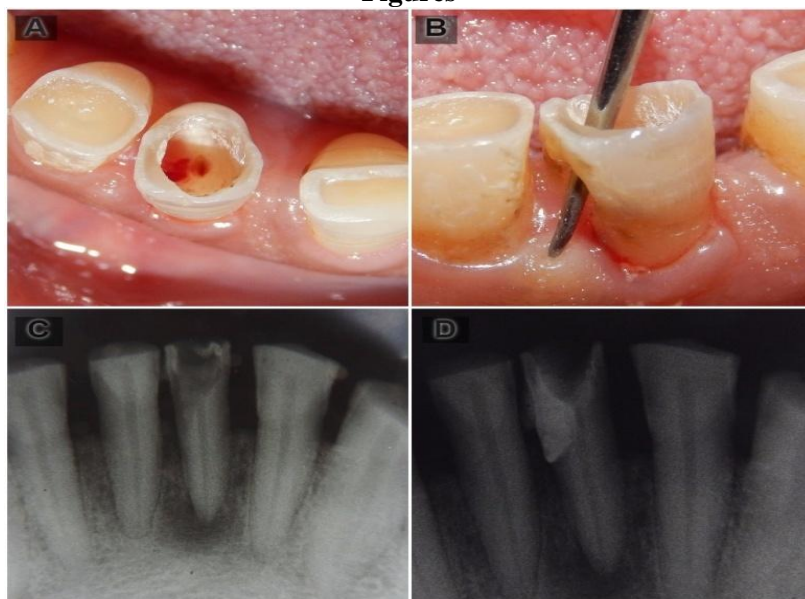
(A) & (B) clinical images showing the perforation (C) radiograph showing the lateral perforation at crestal level (D) radiograph showing the perforation repair using biodentine
